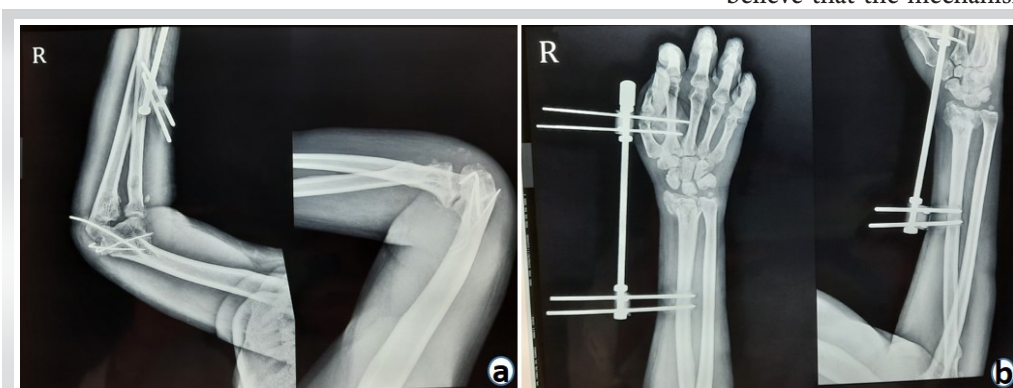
Post-operative X-ray of elbow joint reduction and medial epicondyle fracture fixation comminuted distal radius fracture fixed with forearm distractor.
